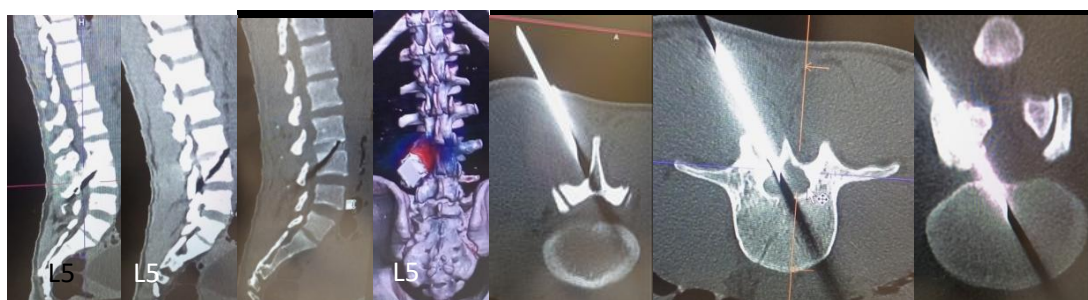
CT scan showing lumbosacralization of S1 with a foreign body passing through the lamina and vertebral body of L5 following an oblique path from the skin to the vertebrae
